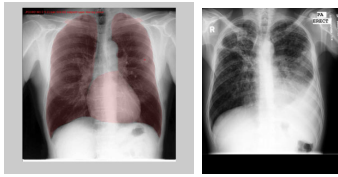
X-rays from the JSRT database with segmentations for lung, heart, and clavicles (left) and from the MC database (right).
